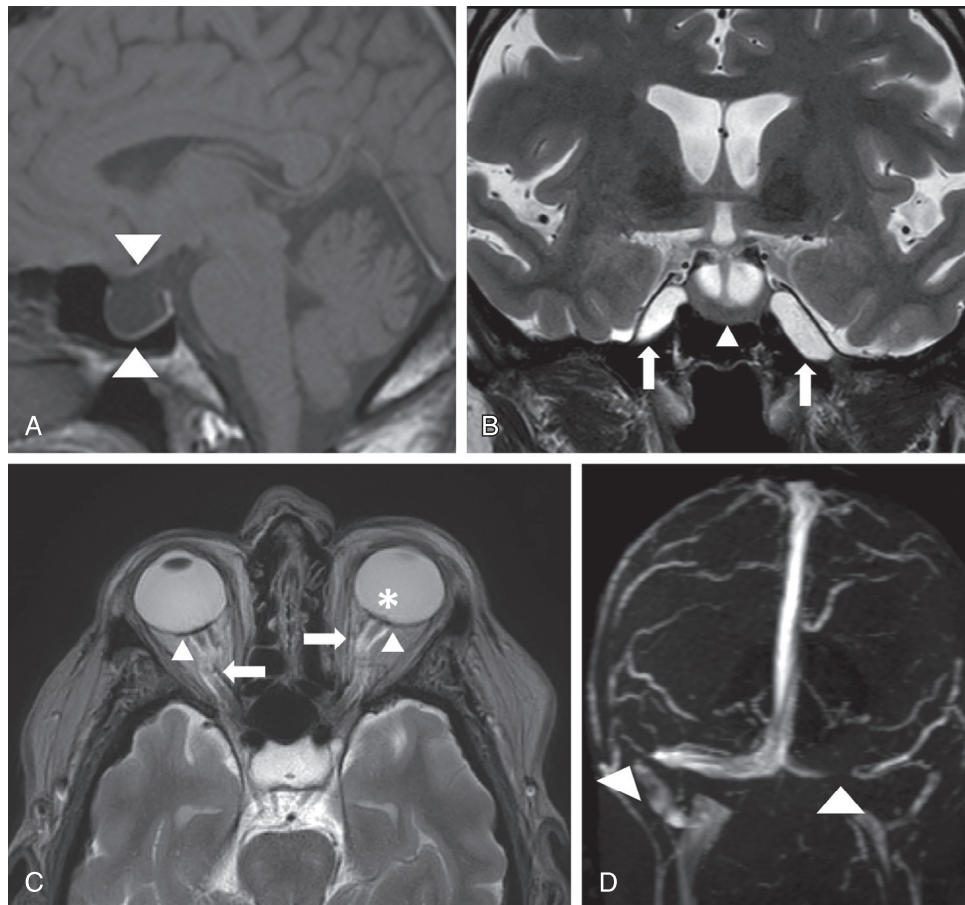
Typical magnetic resonance imaging (MRI) findings of idiopathic intracranial hypertension (IIH). (A) A T1-weighted sagittal image demonstrates a partially empty sella turcica with a flattened pituitary gland (*arrowheads*). (B) A T2-weighted coronal image shows a partially empty sella (*arrowhead*) as well as enlarged bilateral Meckel caves due to meningoceles filled with cerebrospinal fluid (*arrows*). (C) A T2-weighted axial image demonstrates bilateral posterior globe flattening (*arrowheads*), optic nerve sheath distension (*arrows*), and optic nerve head protrusion into the posterior globe (*asterisk*). (D) A time-of-flight MR venogram of a patient with IIH demonstrates narrowed right distal transverse/proximal sigmoid sinuses and severe narrowing at left mid-transverse sinus (*arrowheads*).
